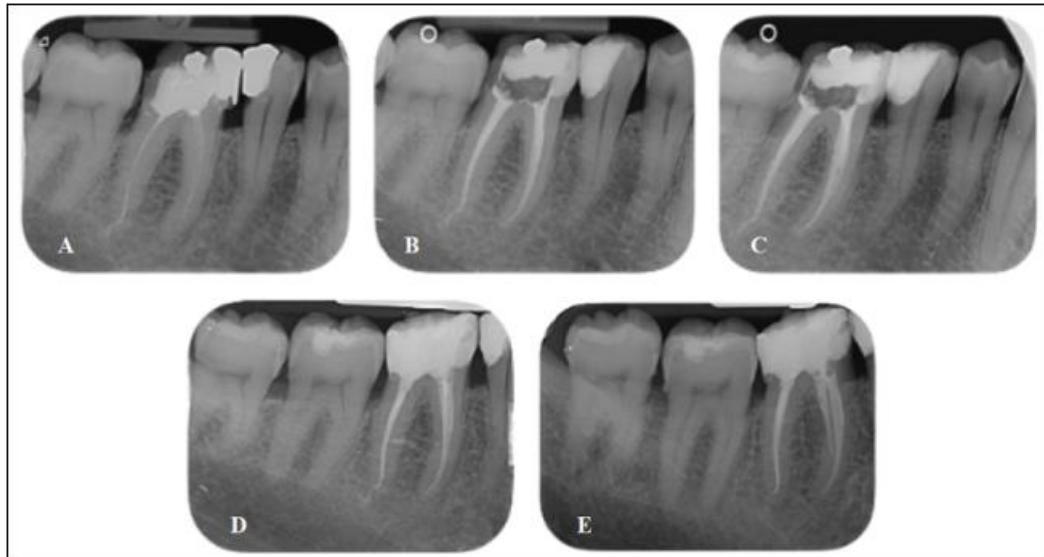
A) The initial radiograph on tooth #47-PAI3, B) Control radiograph after the root canal obturation; C) Control radiograph 2 years after the obturation of the root canals; D) 4 years follow-up-PAI. E) 7 years follow-up-PAI1.
